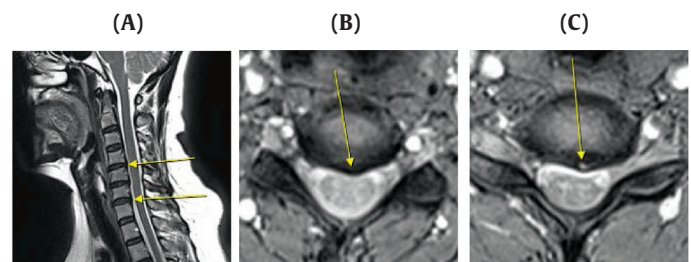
Cervical spine MRI (T2-weighted image) of Case 1 on July 02, 2018. (A) Sagittal (B) Axial C4-5 (C) Axial C6-7. MRI, magnetic resonance imaging.
